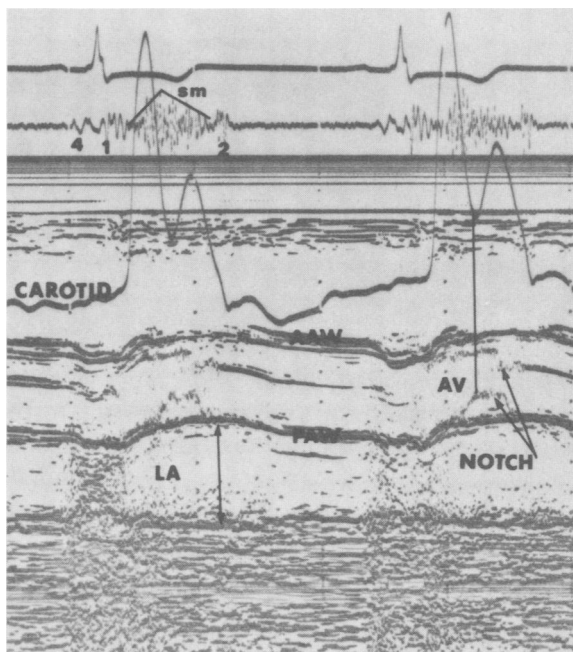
Preoperative echocardiogram of aortic valve. Note the systolic notch of the aortic valve (AV) consistent with dynamic left ventricular outflow tract obstruction. This nicely correlates with the bifid carotid pulse tracing. The left atrium (LA) is normal in size. The phonocardiogram trace (from left lower sternal border) at the top of the figure shows the first (S_1) and second (S_2) heart sounds, an atrial filling gallop (S_4) and a crescendo-decrescendo murmur (outlined with solid lines). AAW = anterior aortic wall. PAW = posterior aortic wall.
